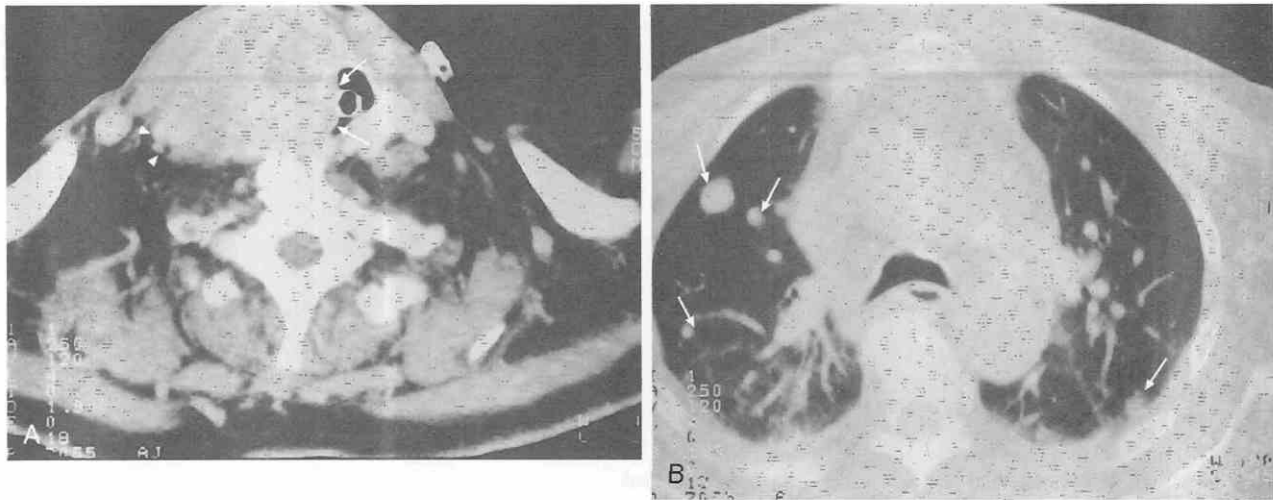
Anaplastic thyroid carcinoma. *A*, Axial postcontrast CT scan shows a large right thyroid lobe mass with tracheal invasion (arrows). The lesion marginates but does not surround the right common carotid artery (arrowheads). An endotracheal tube is in place. *B*, Axial CT scan through the thorax in the same patient shows multiple pulmonary metastases (arrows).
